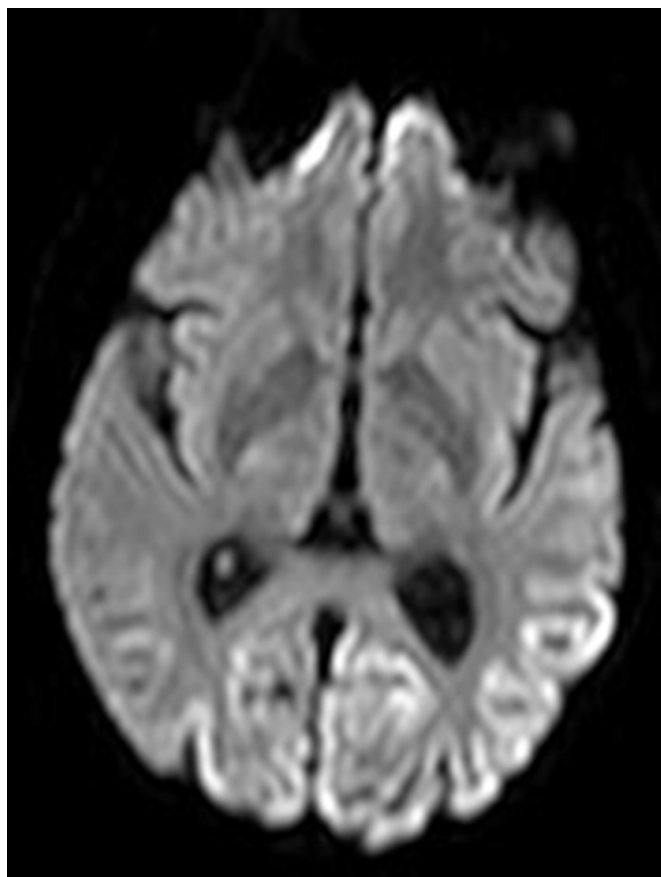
■ Creutzfeldt–Jakob disease. Diffusion-weighted MRI image showing restricted diffusion within the cortical ribbon of the posterior hemispheres bilaterally.
